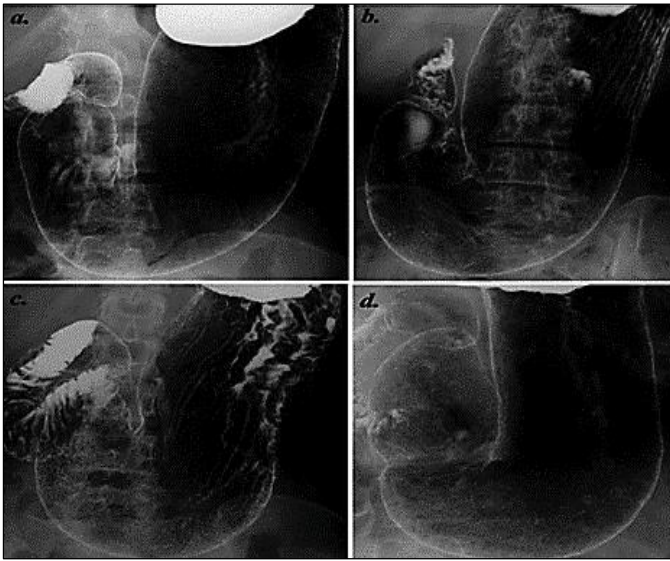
Contrast radiographic of GIT
